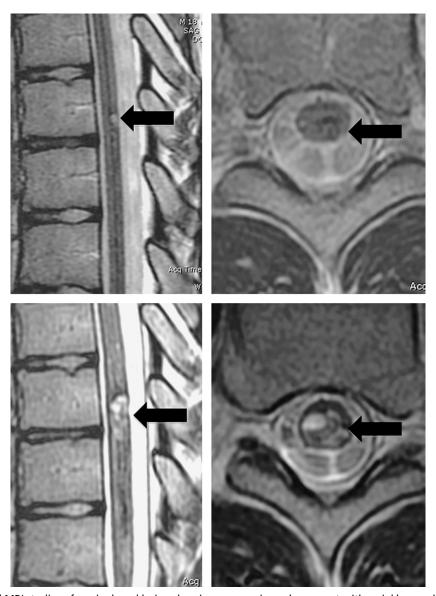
Serial MRI studies of a spinal cord lesion showing progressive enlargement with serial hemorrhages. These images were taken 6 months apart, with 2 distinct presentations of lower extremity sensory changes, weakness, and urinary incontinence. Each time the child made a recovery from the presentation examination, but never returned to his neurologic baseline and worsened with subsequent hemorrhages (operative photograph in Fig. 1).
